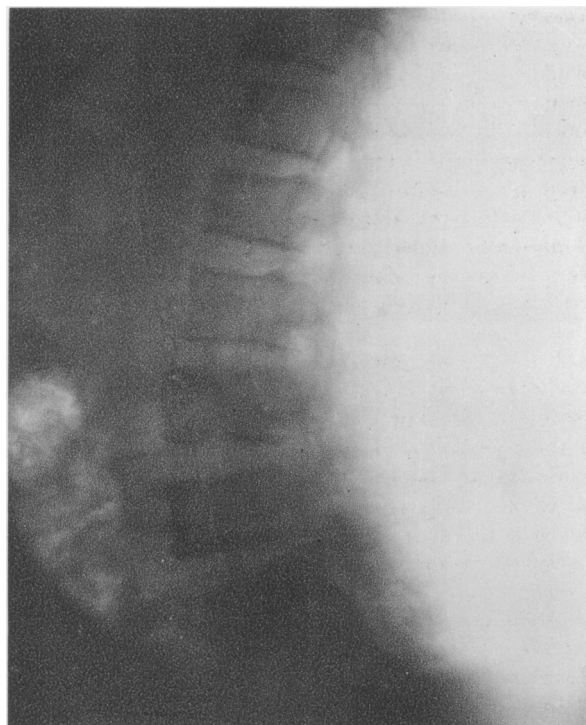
Radiograph taken on August 13th, 1931.
